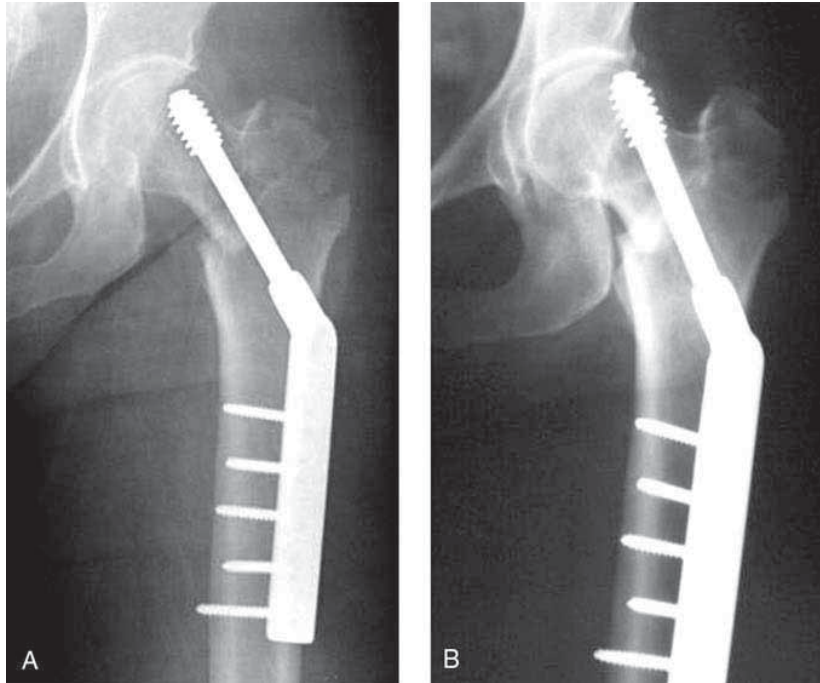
AP radiographs of the proximal femur showing lag screw cutout caused by unstable fracture reduction and improper implant positioning. A, Malpositioned lag screw. B, Cutout from the femoral head.
